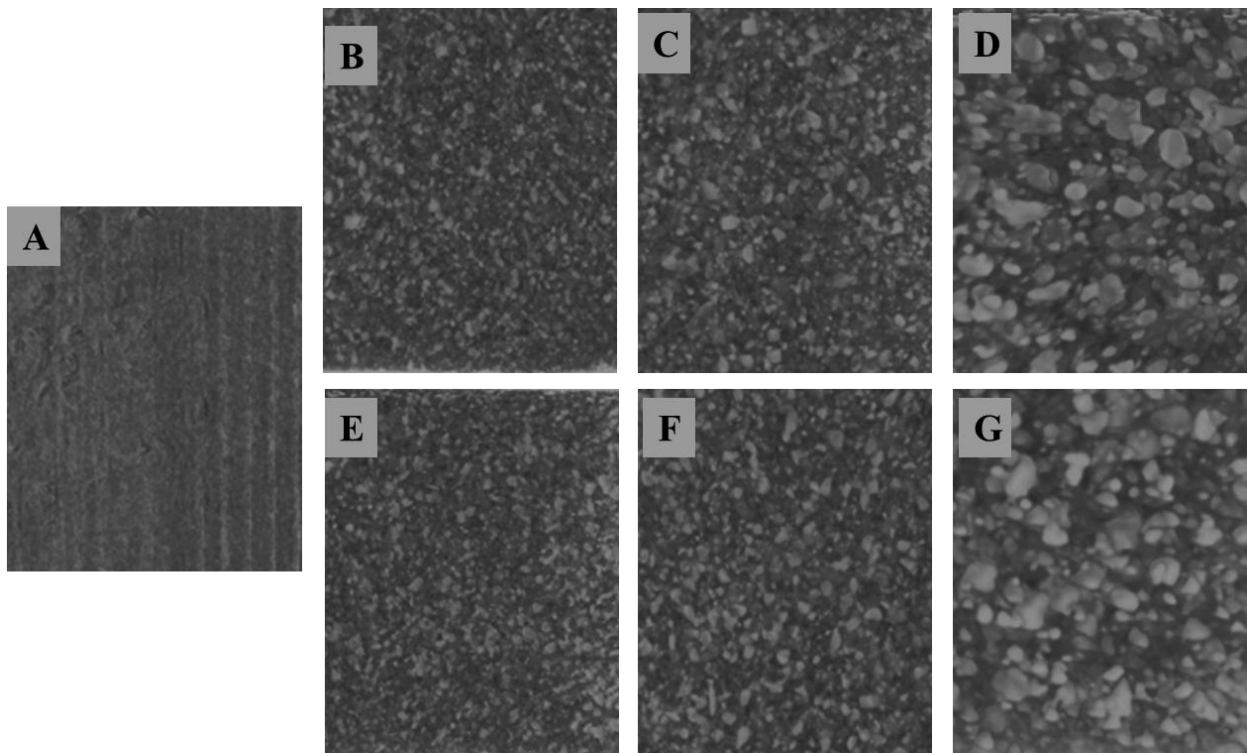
μ -CT analysis of 3D printed samples (A) PEEK, (B) PEEK/10SrHA (C) PEEK/20SrHA, (D) PEEK/30SrHA, (E) PEEK/10ZnHA, (F) PEEK/20ZnHA, (G) PEEK/30ZnHA
